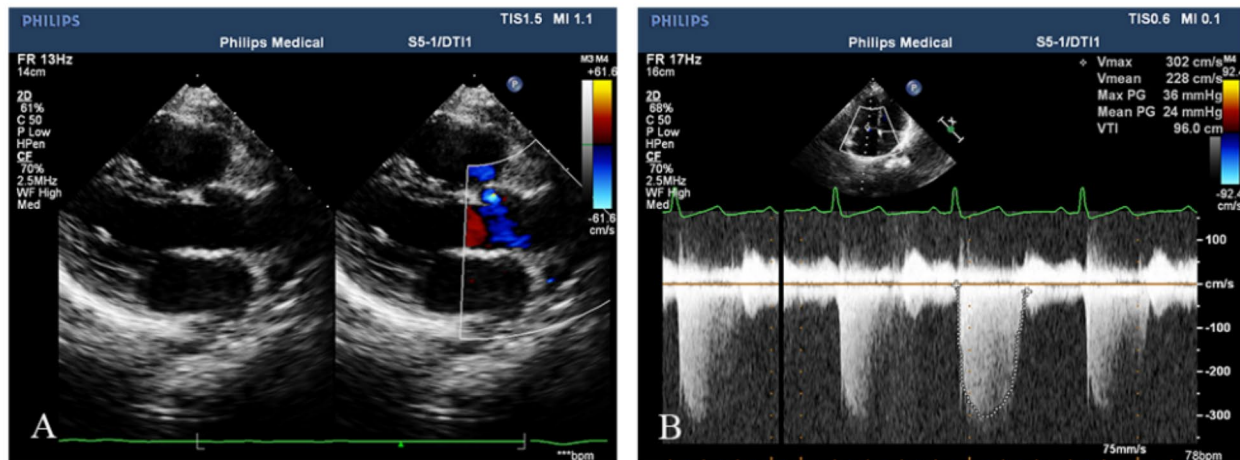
Transthoracic echocardiography after the operation. (A) The abnormal pulmonary artery origin sign has disappeared. (B) Pulmonary artery pressure is estimated by tricuspid regurgitation
